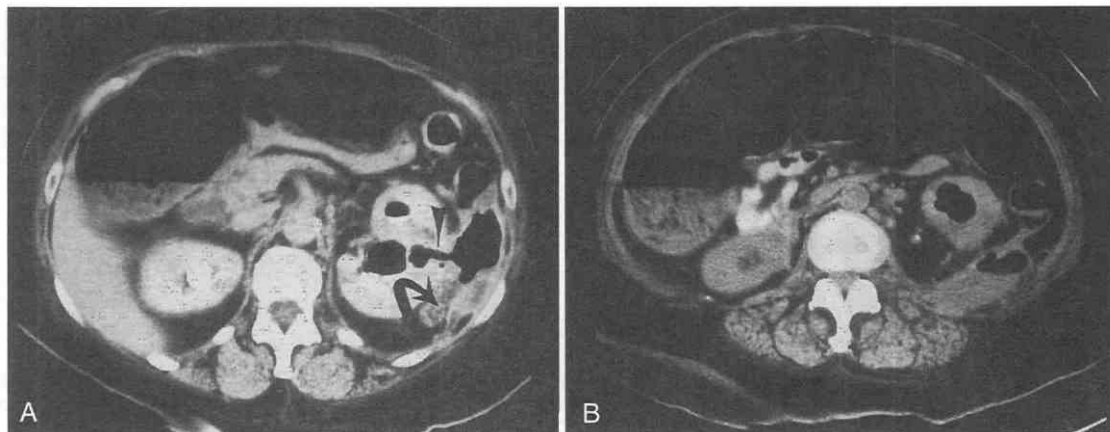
Emphysematous pyelonephritis. A, CT scan showing fistula (arrowhead) from the colon into the left kidney. Note the abscess extension (curved arrow) into the posterior pararenal space. B, This lower scan shows air within the left kidney and the air-fluid level in the pararenal space (arrow).
